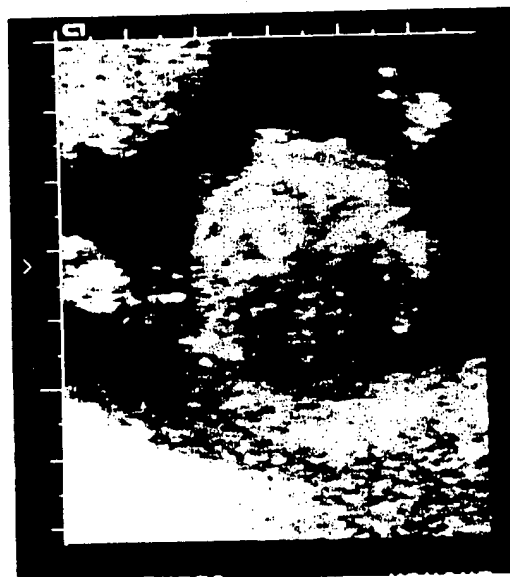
Sonogram showing view of fetal face in the coronal plane at 18 weeks
